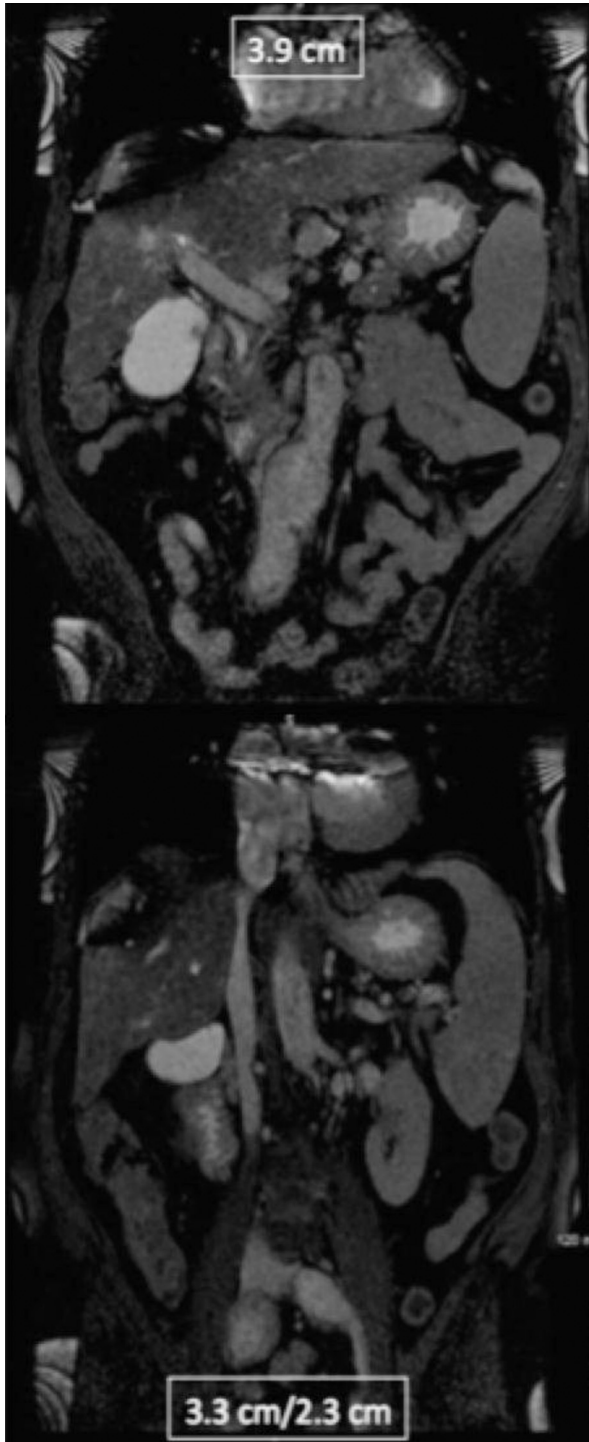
Magnetic resonance imaging of the abdomen and pelvis, November 2013.
